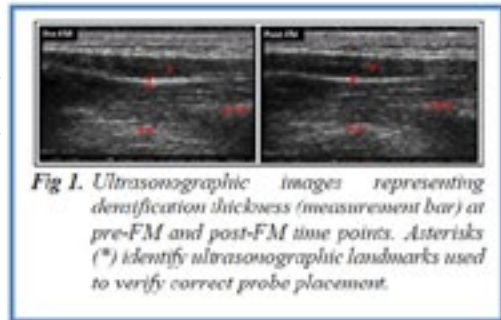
Ultrasonographic images representing densification thickness (measurement bar) at pre-FM and post-FM time points. Asterisks () identify ultrasonographic landmarks used to verify correct probe placement.*
